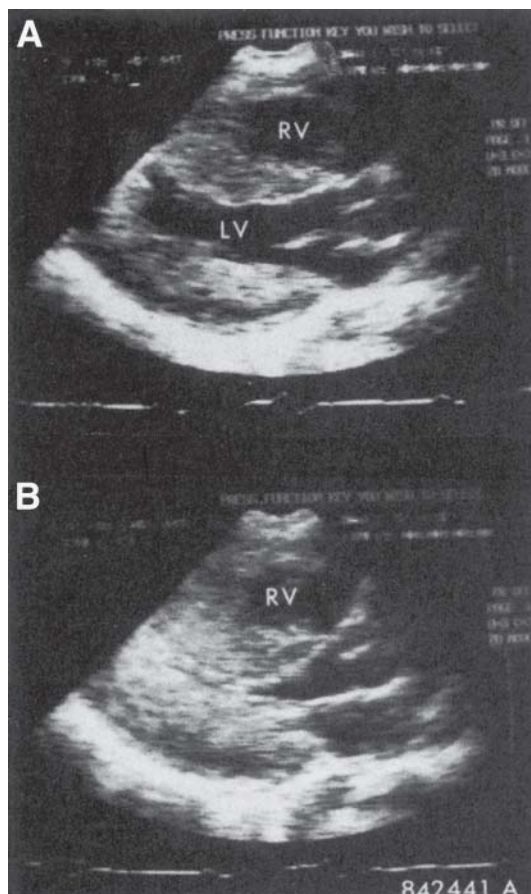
Long-axis two-dimensional echocardiogram of a patient with hypertrophic cardiomyopathy who exhibits uniform hypertrophy of the entire left ventricle (LV). LV, left ventricle; RV, right ventricle; (A) diastole; (B) systole. From Feigenbaum H. Echocardiography. Fourth edition. Philadelphia: Lea & Febiger, 1986:518. Reprinted with permission.
